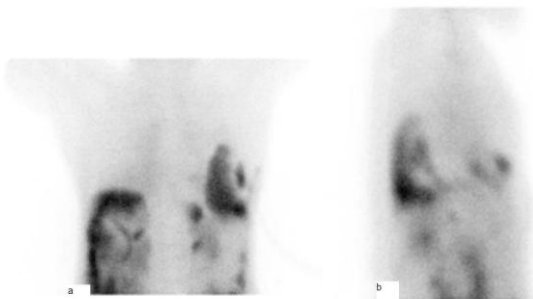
Peritoneal scintigraphy: Posterior (a) and right lateral (b) thorax views showing migration of radioactivity into the right pleural cavity.
